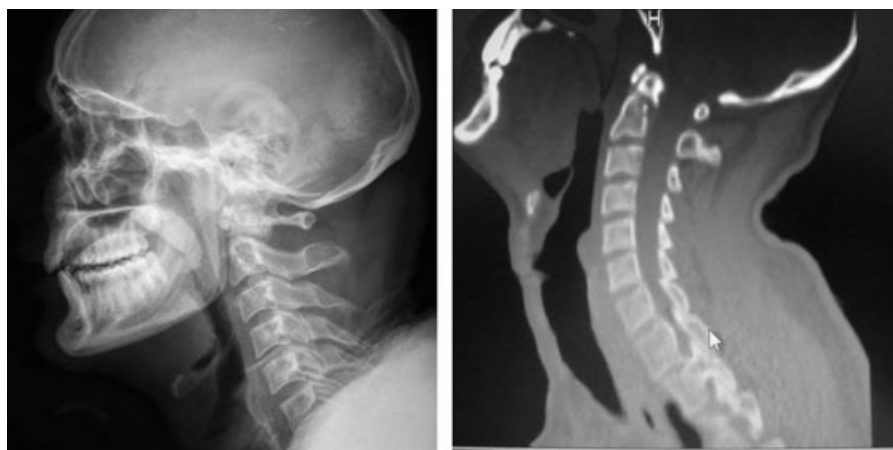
Fractured odontoid process of C2 clearly visible only in CT scan (JPG, 960–720 pixels). CT, computed tomography.
